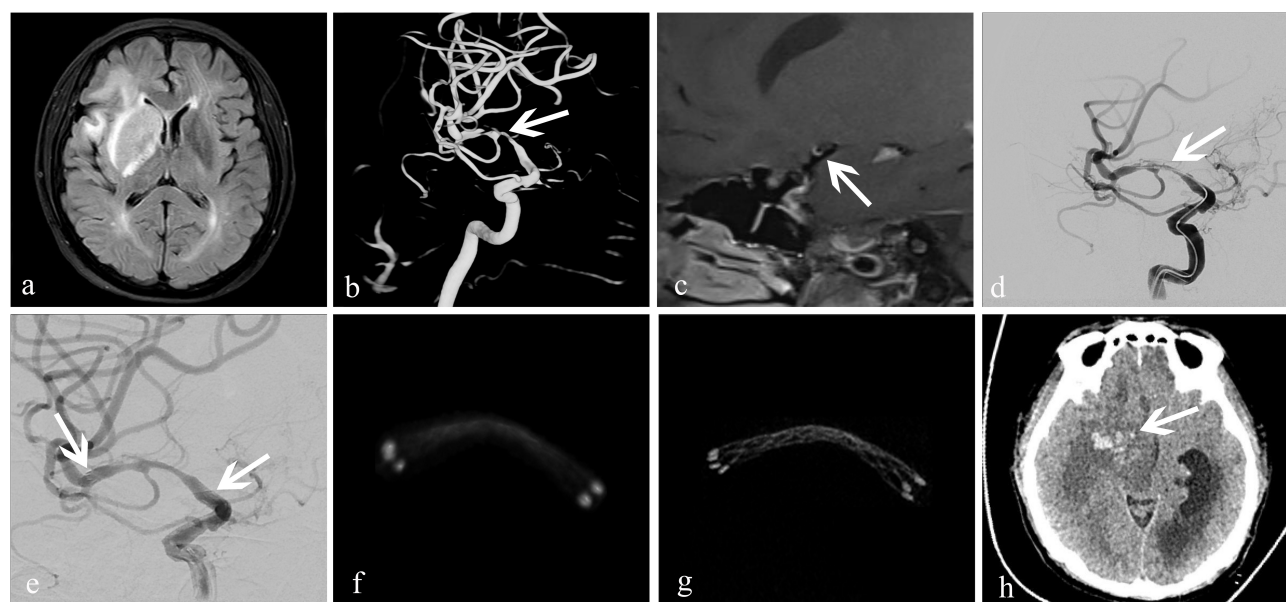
Treatment of an atherosclerotic stenosis in the right middle cerebral artery with the Enterprise™ stent. A 52-year-old woman who presented with left-limb weakness of 12-day duration. (a) MRI showed subacute cerebral infarction in the right temporal lobe and basal ganglia; (b) 3D-DSA revealed severe stenosis (83%) at the bifurcation of the right middle cerebral artery (white arrow); (c) high-resolution MRI showed that the stenosis was atherosclerotic (white arrow); (d,e) dilation using a Gateway™ balloon was done followed by insertion of an Enterprise stent measuring 4.5 mm × 22 mm (white arrow). Residual stenosis was 28%; the two arrows in (e) showed both ends of the stent. (f) conventional FDCT showed a good position of the distal and proximal stent markers, but the stent itself was poorly visualized with an image-quality score of 0; (g) HR-FDCT showed good deployment of the stent, and the image quality was improved significantly with a score of 2; (h) 6-h later, CT of the head showed cerebral parenchymal hemorrhage (white arrow) in the former infarction area at right basal ganglia.
